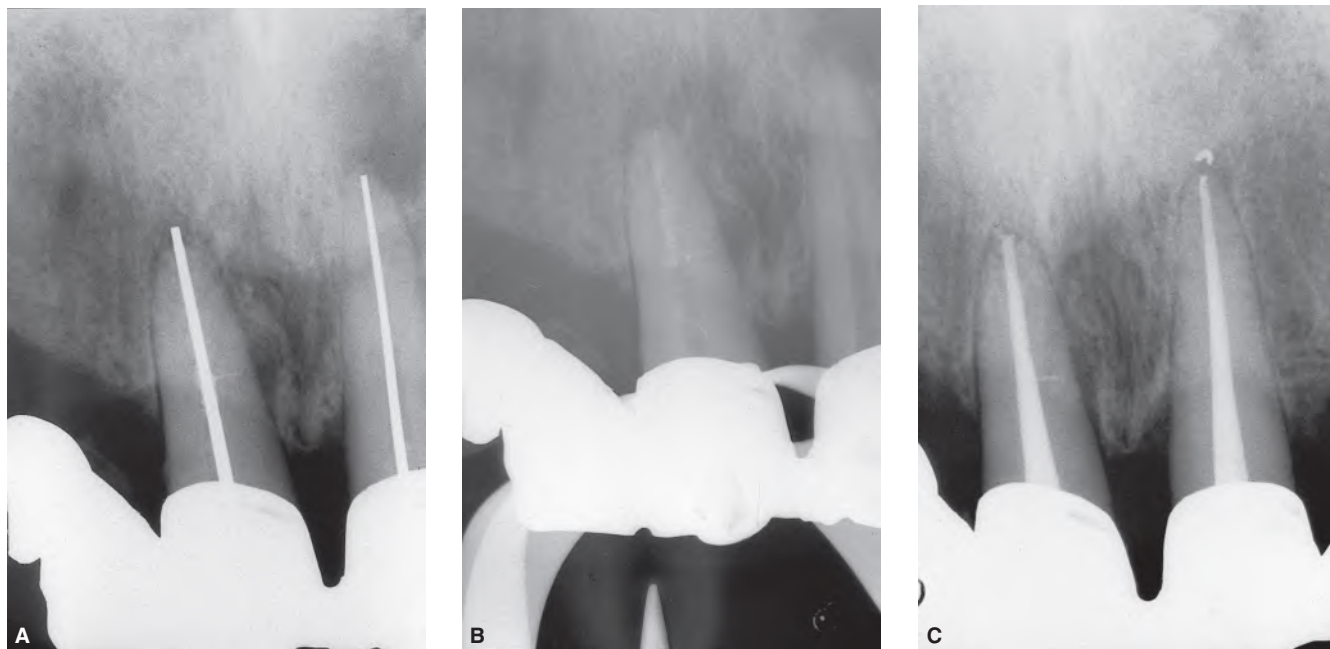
A. A maxillary right central incisor obturated with a silver cone presenting periradicular radiolucencies. Note sealer extruding via a small lateral canal midway along the root. B. The silver cone was removed. C. Three years later, the periapical lesions associated with the two central incisors have resolved. However, the lateral lesion associated with the right central incisor has not completely resolved. It is possible that some infected material is still present within the lateral canal.
